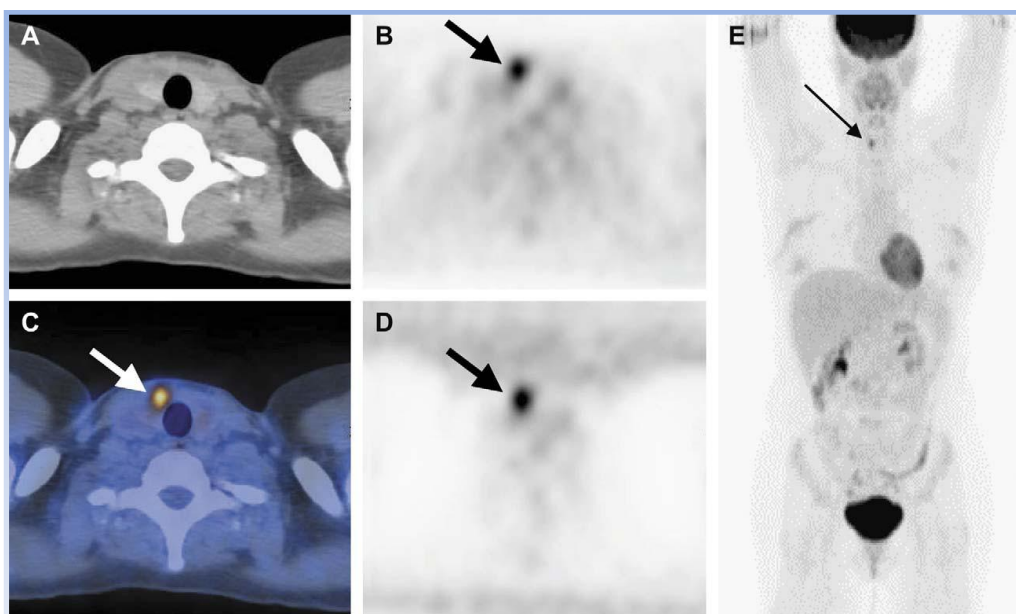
^{18}F FDG-PET/CT of a patient with a nodule in the right lobe of the thyroid. A) CT scan alone, B) PET scan without attenuation correction, D) PET scan with attenuation correction, C) fused PET/CT and E) whole-body scout. Thyroid nodule is seen in PET and CT scans (arrows). Pathologic examination revealed that this patient had a 1.2-cm papillary cancer (36).
